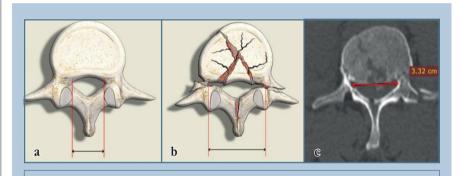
Determination of the interpedicular distance on axial sections: $\bf a$ – the interpedicular distance for a vertebra without fracture; $\bf b$ – a burst compression fracture with an extension of the interpedicular distance; $\bf c$ – measurement of the interpedicular distance on CT (Dicom catalog)
